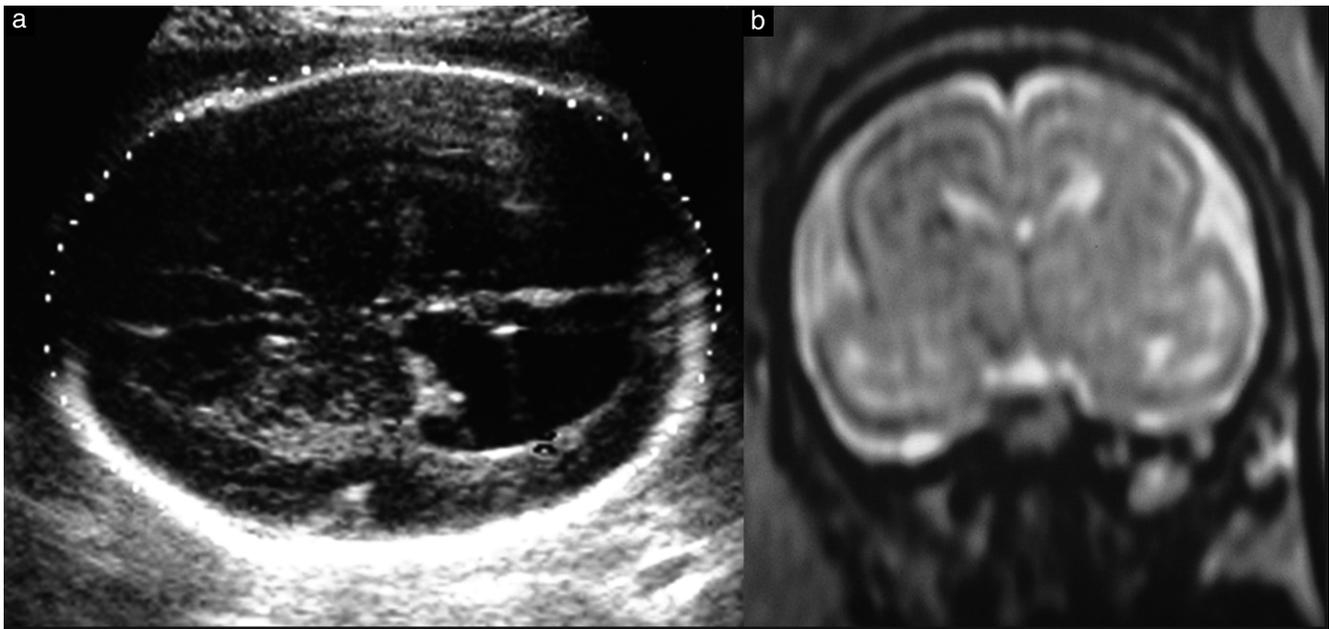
Fetal imaging in a patient referred at 28 gestational weeks due to ventriculomegaly and severe reduction in cephalic biometry. (a) Axial sonographic image showing an echogenic periventricular area and abnormal operculization of the Sylvian fissure, demonstrating rudimentary and moderate ventriculomegaly. Cephalic biometry corresponded to the 50th percentile at 24.5 weeks, equivalent to a decrease close to -3 SD. (b) Coronal T2-weighted magnetic resonance image (MRI) confirming suspicion of gyral anomalies, demonstrating a typical figure-of-eight-shaped appearance of the brain, with a thick cortex and smooth surface suggestive of lissencephaly Type 1, which was confirmed on postnatal MRI. Note that the echogenic periventricular area on sonographic examination was associated with abnormal waves of neuronal migration, as shown by MRI.
